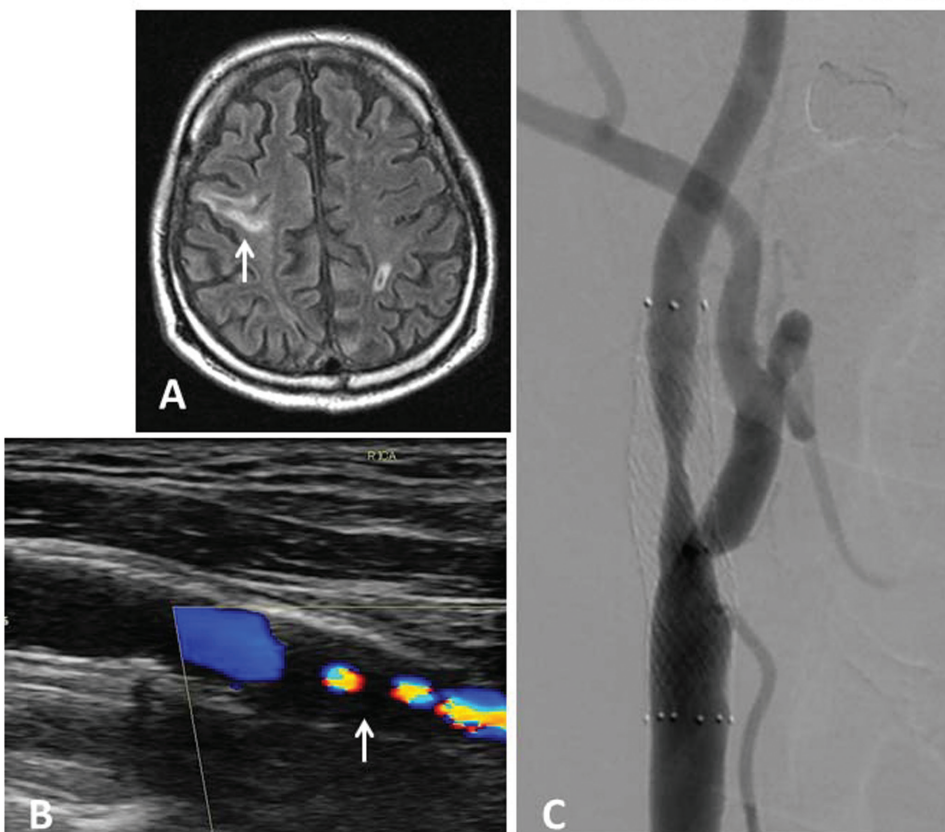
A: Magnetic resonance imaging demonstrating ischemic lesion (arrow) on the right cerebral hemisphere. B: Cervical ultrasound image showing intimal thickness with low-echoic signal (arrow). C: Angiography on admission revealing more progressive in-stent restenosis and previous stent enlargement.
